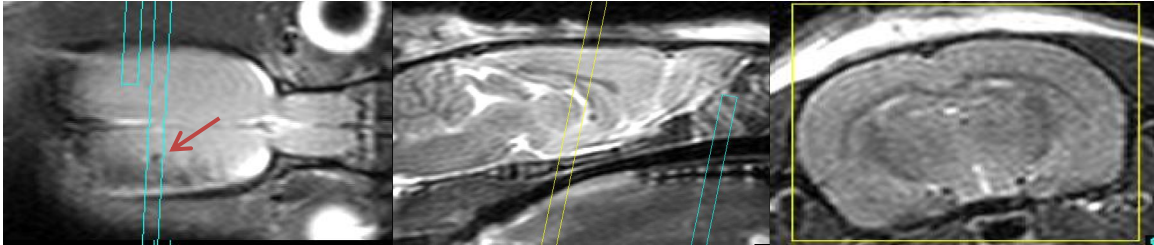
MRI slice selection procedure. Representative single slice *in vivo* images, from T2w FSE multislice acquisition, in orthogonal orientations a) coronal, b) sagittal and c) axial plane used to locate the injection site. Cyan and yellow boxes indicate the slice prescription for single slice qMT and multislice DTI acquisition. Above image is representative for cases where the needle track is not clearly visible in axial sections. However, notice the damaged region is clearly visible in coronal section indicated by red arrow.
